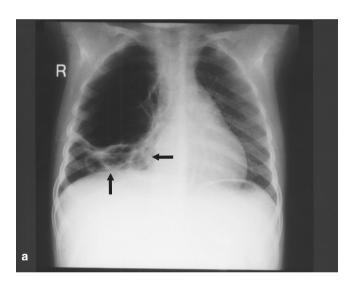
Initial imaging at second presentation. (a) Radiograph demonstrates a large pneumatocele of the right upper lobe (white arrows) and acute infective change in the lower lobe (black arrow). (b) CT scan confirms the pneumatocele in the right upper lobe (arrows) without intracavitory body or fluid level.
